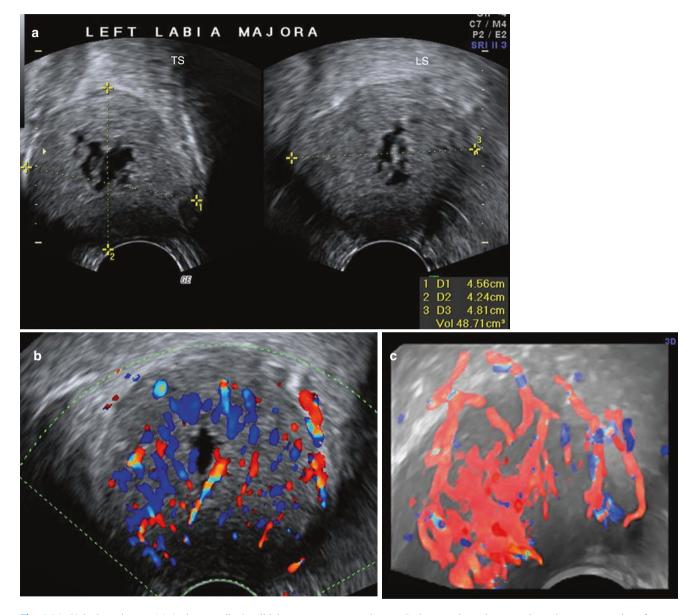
Vulval carcinoma. (a) A circumscribed, solid, heterogeneous mass is seen. It shows an irregular, central, cystic area suggestive of necrosis. (b) The mass shows high vascularity (colour score of 4). (c) 3D Doppler with glass body display shows abnormal vascular morphology of the mass
